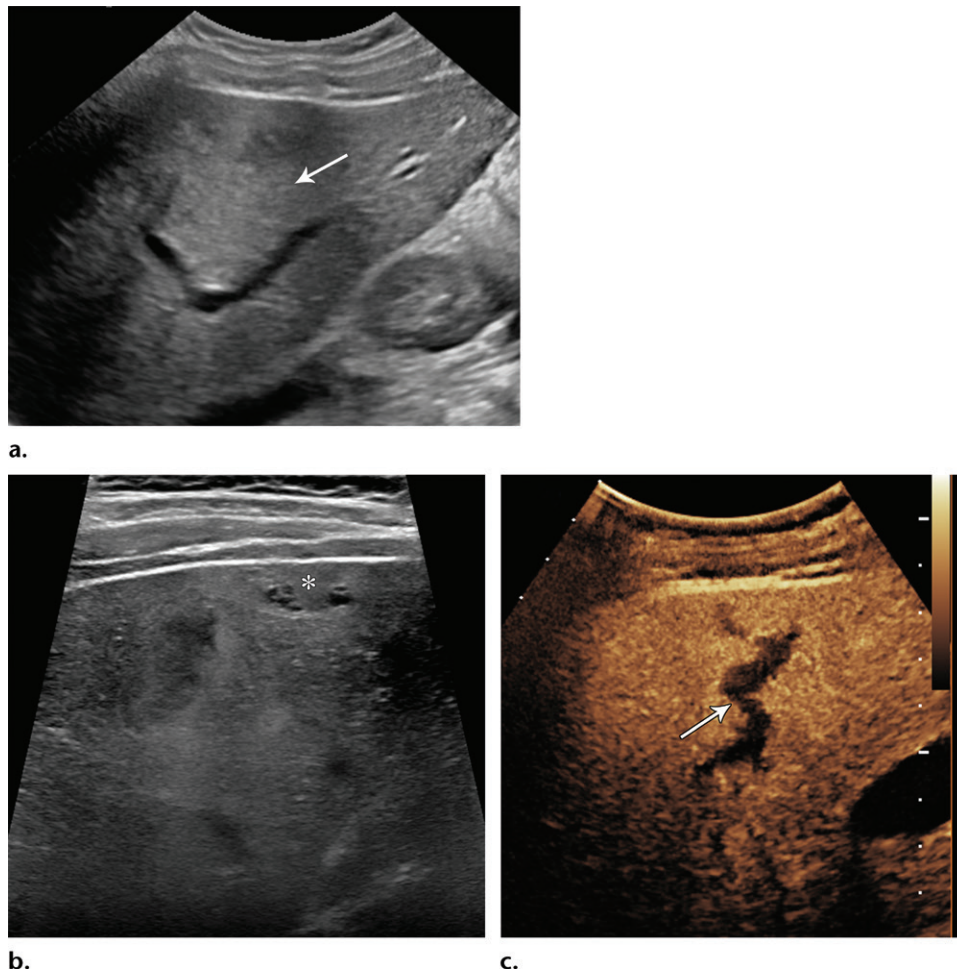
Liver laceration in a 7-year-old girl who fell while playing laser tag. (a, b) Sagittal (a) and transverse (b) gray-scale US images of an area of the liver with increased echogenicity (arrow in a) and a subcapsular collection of blood products (* in b) show no laceration. (c) Sagittal CEUS image shows a serpiginous hypoechoic defect (arrow), consistent with a grade 3 liver laceration (according to the American Association for the Surgery of Trauma scoring system), that is easily differentiated from the normal enhancing liver parenchyma. Performing CEUS in this hemodynamically stable child with a low-energy blunt trauma lesion obviated CT, enabling her to avoid ionizing radiation exposure and iodinated contrast material administration.
